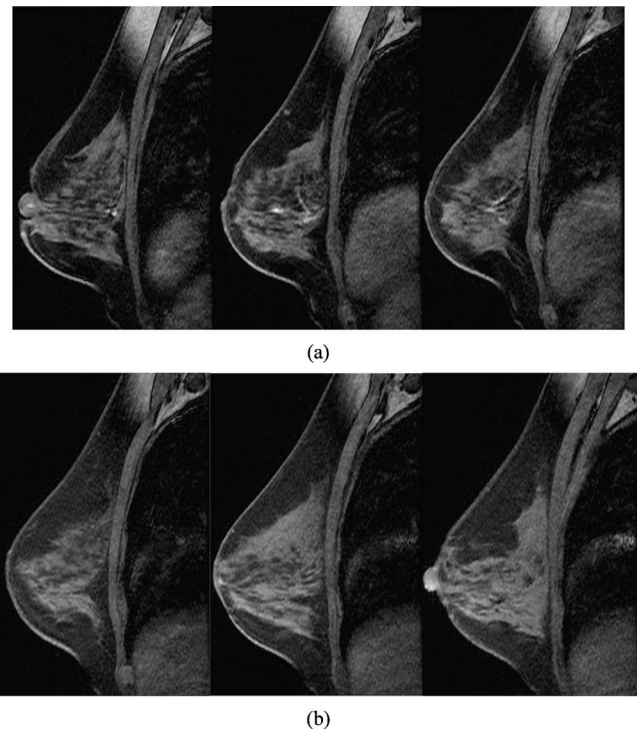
A MRI image of the case in Fig. 1. (a) The sagittal slices 26, 33, and 36 of 3-D MRI image of right breast. (b) The sagittal slices 116, 122, and 130 of 3-D MRI image of left breast.
